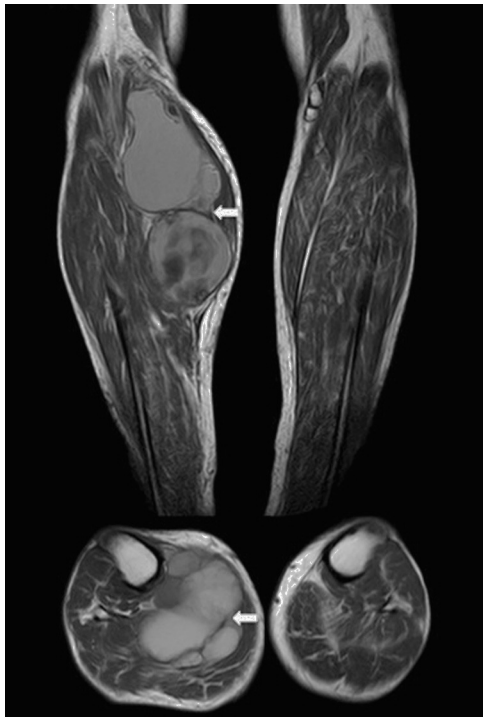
MR. Axial and coronal T1-weighted images. Well circumscribed mass (arrows). Increased intensity signal compatible with a subacute presence of blood products.
